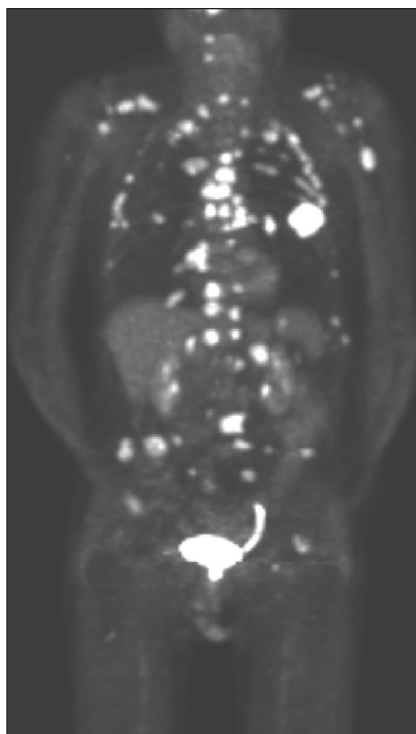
Images of an abnormal positron emission tomography scan showing cancer in the left lung with extensive mediastinal disease and bone metastasis not detected on bone scan, bone radiographs or computed tomography (CT) scans. Only the lung mass was seen on a CT scan. The patient died 1 month later.
